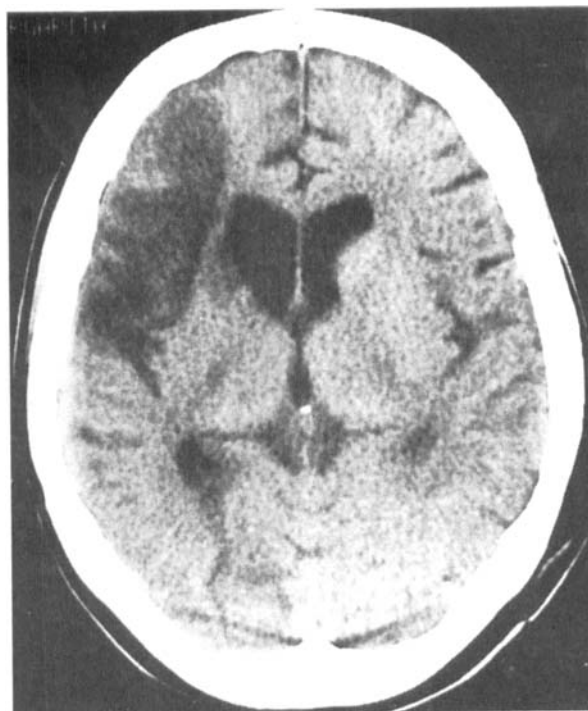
CT scan with contrast. Right ischemic lesion involving regions of the anterior and middle cerebral arteries.
